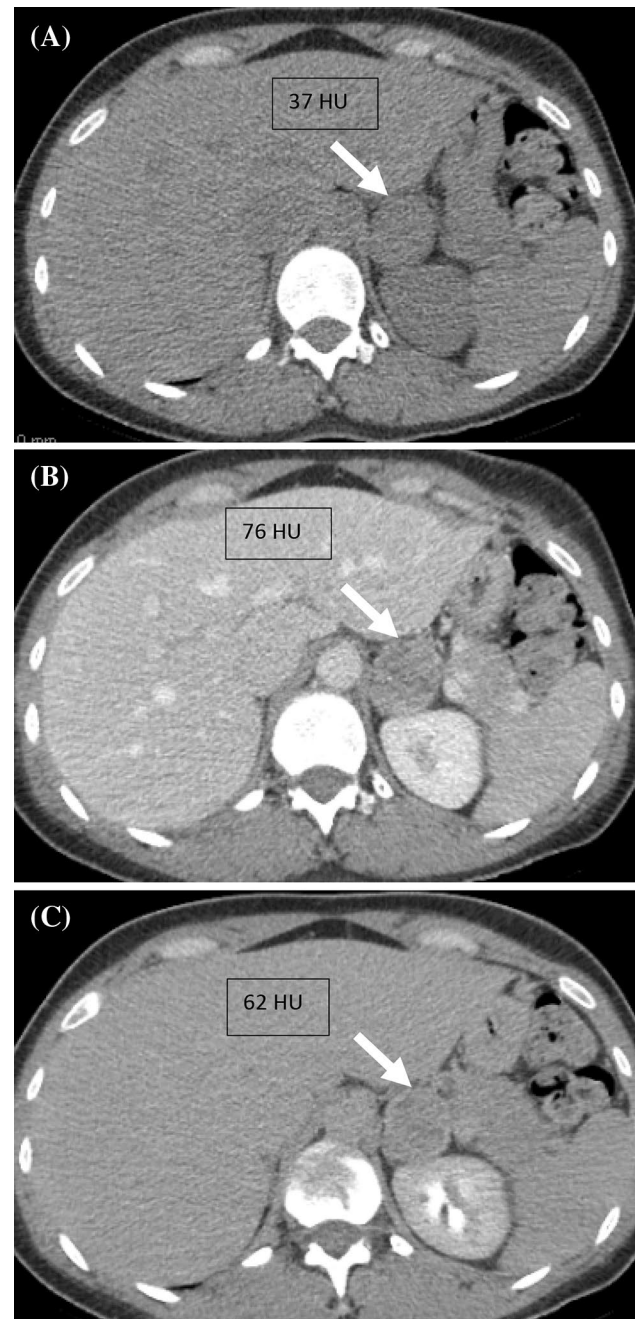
A 53-year-old female with incidentally discovered left adrenal mass (white arrows). Axial non-contrast (a), venous (b), and delayed (c) post-contrast CT images show a left adrenal mass with attenuation values of 37 HU, 76 HU, and 62 HU in the non-contrast, venous, and delayed images, respectively. The absolute washout for this lesion is 35.9%, and the relative washout is 18.4%. The washout was not consistent with adenoma. This mass was pathologically proven ACC
